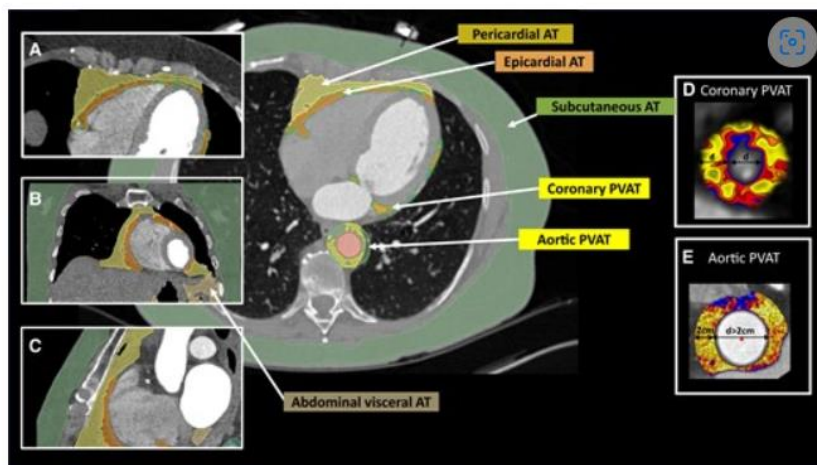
Imaging of human adipose tissue depots by computed tomography. Axial (A), coronal (B), and sagittal (C) views of the chest showing subcutaneous, visceral abdominal, thoracic (including the pericardial and epicardial) adipose tissue. Reconstruction of perivascular adipose tissue (PVAT) around an epicardial coronary artery (D) and thoracic aorta (E). PVAT is defined as the adipose tissue lying within a radial distance from the outer vessel wall equal to the vessel diameter (or at a maximum distance of 2 cm in the case of large vessels with diameter >2 cm, like the aorta).
